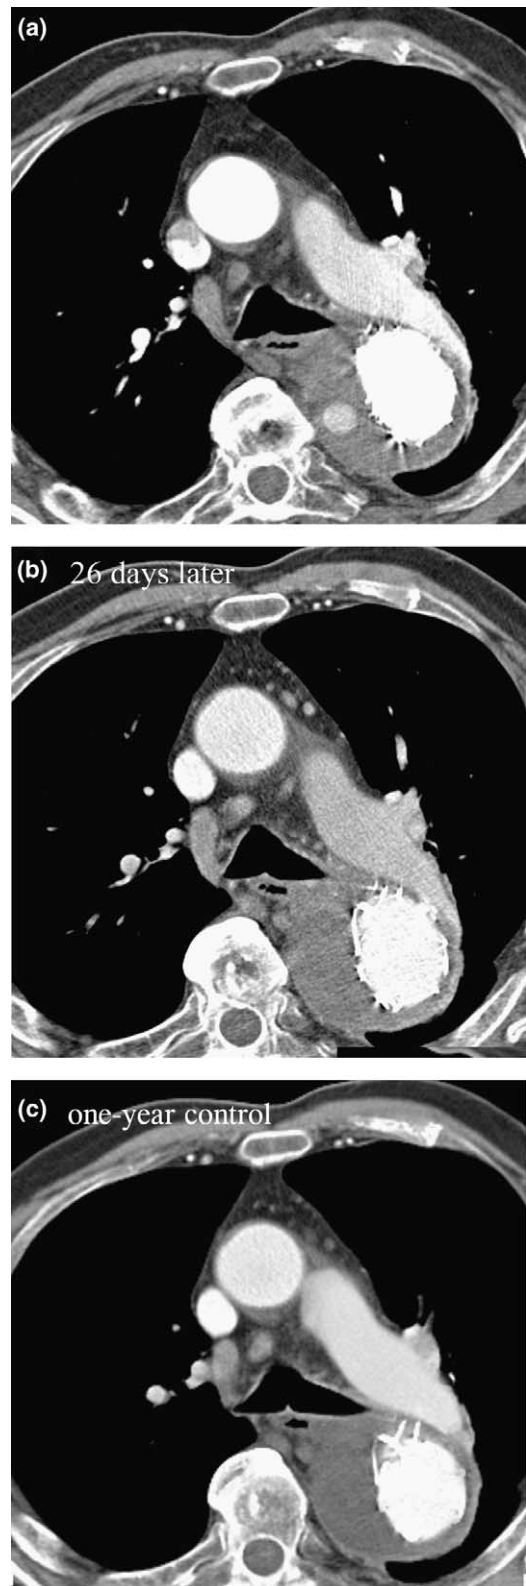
Aortic-thoracic CTA at the same level before (a) and after embolization procedure (b) show thrombosis of the previous perfused false lumen 26 days after the intervention (c) one year CT after initial diagnosis shows permanent thrombosis of the false lumen after the endoluminal embolization.
